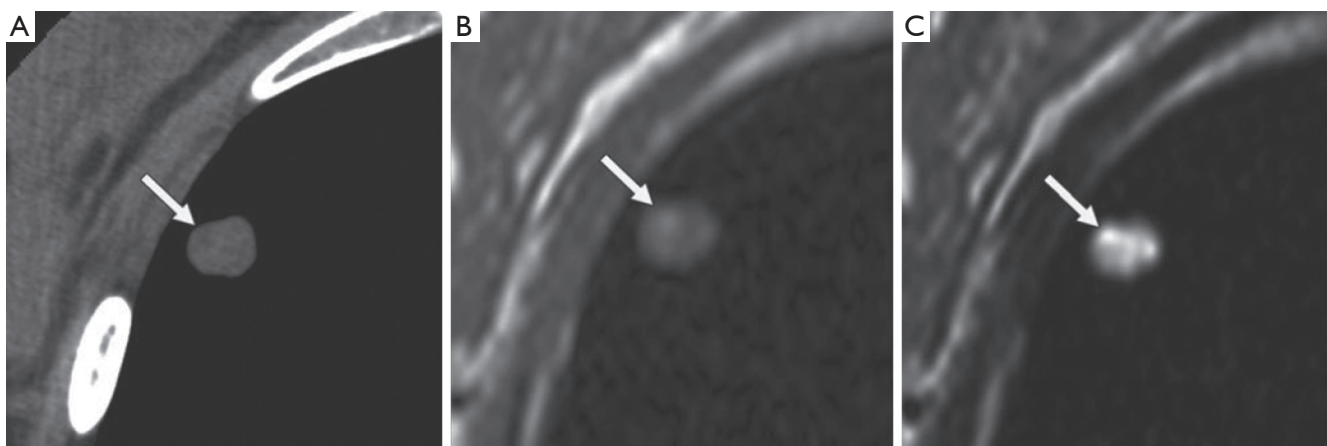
A 40-year-old woman with pulmonary hamartoma. (A) CT image shows low-attenuation spot (arrow) within nodule, suggesting lipid tissue; (B,C) axial T1-weighted (B) and T2-weighted (C) MR images show hyperintense spots (arrows) within nodule. T2-weighted image (C) also shows hyper-intense matrix consistent with cartilaginous tissue [Reproduced with permission from reference (21)].
